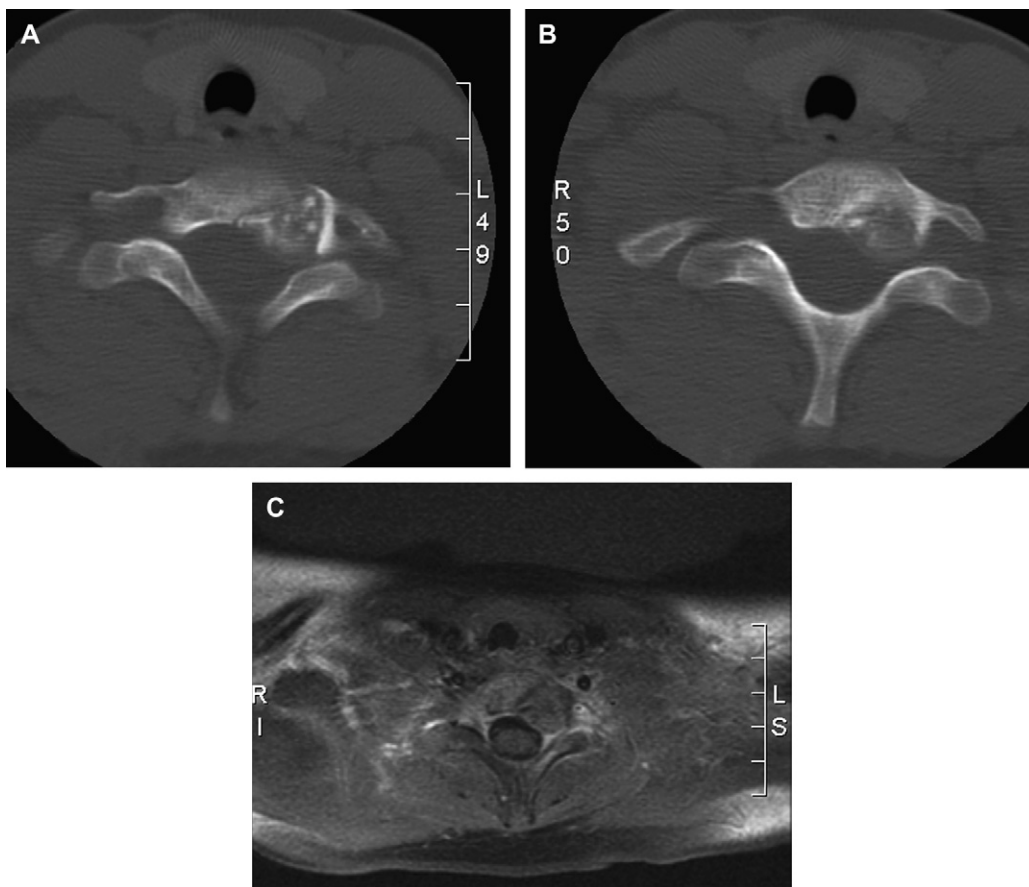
An 8-year-old boy presented with neck pain. (A, B) Axial CT scans revealed an expansile, lytic, destructive lesion involving the left pedicle and the base of the posterior arch of C7. (C) Axial T1-weighted image with contrast of the same patient demonstrated an expansile lesion with a nidus of enhancement. Pathologic analysis revealed osteoblastoma.
